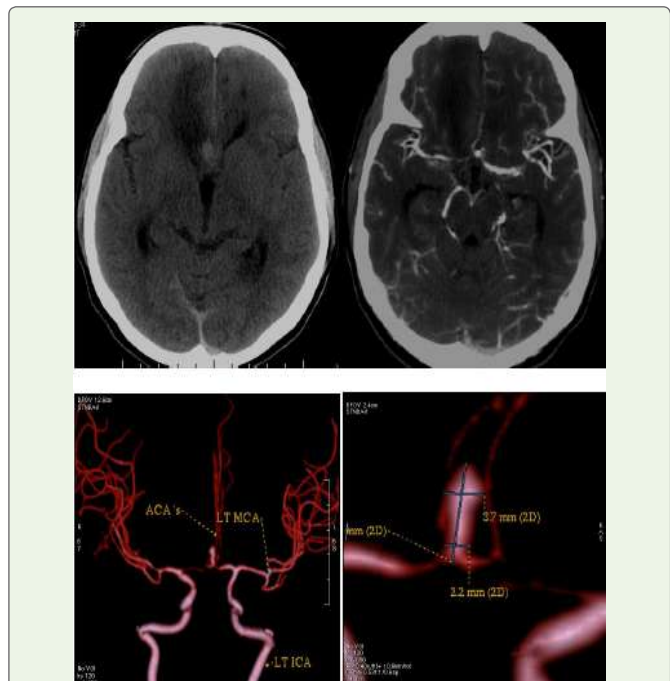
Right frontal lobe infarct is seen on CT Axial non-contrast (A), MIP (B), and 3D-VR images (C, D) show a large ACOM saccular aneurysm with a neck diameter of 2.2 mm and a high ellipticity index, squeezing the right ACA's A2 segment and generating a mass effect. He was scheduled for immediate endovascular treatment but did not show up for the follow-up.
